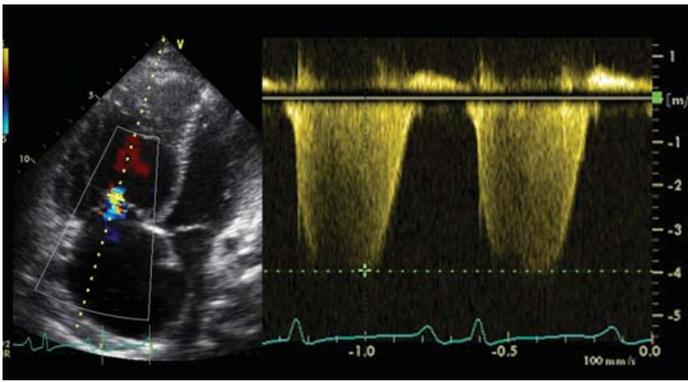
CW-Doppler assessment of the tricuspid regurgitation velocity. The CW-Doppler is guided by the color Doppler to obtain the tricuspid regurgitation jet within the correct angle. The regurgitation velocity profiles (on right) should be obtained by color Doppler spectral imaging and with a sweep velocity of at least 100-200 mm/s in order to measure the maximal velocity at the true edge of the profiles. The systolic pulmonary artery pressure (PASP) will be calculated by a modified Bernoulli equation, where $PASP = (V_{max}^2 \times 4) +$ estimated right atrial pressure.
